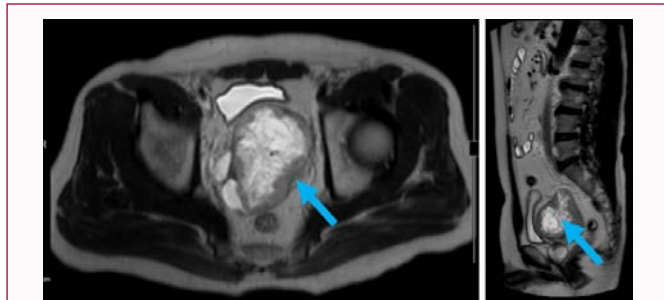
MRI demonstrated a large lobulated mass in the pelvic cavity, which appeared to be of hyperintense density in the central area on T2WI (arrow).
